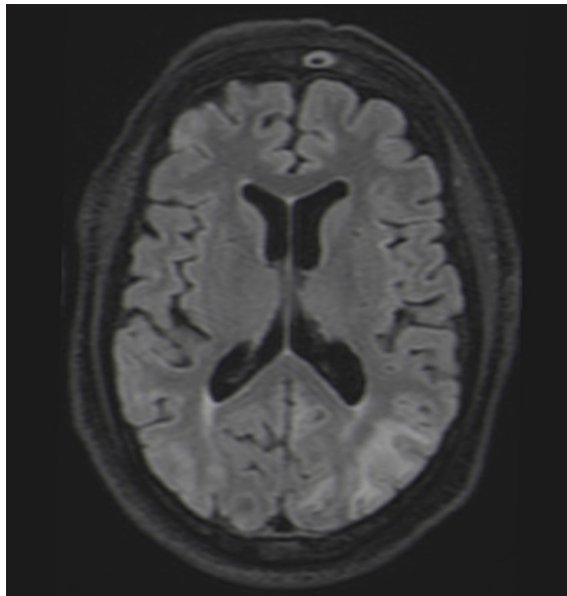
Extensive lesion areas with hyperintense expression on FLAIR sequences, predominantly involving the temporal-occipito-parietal subcortical white matter bilaterally, with greater parietal predominance on the right.
